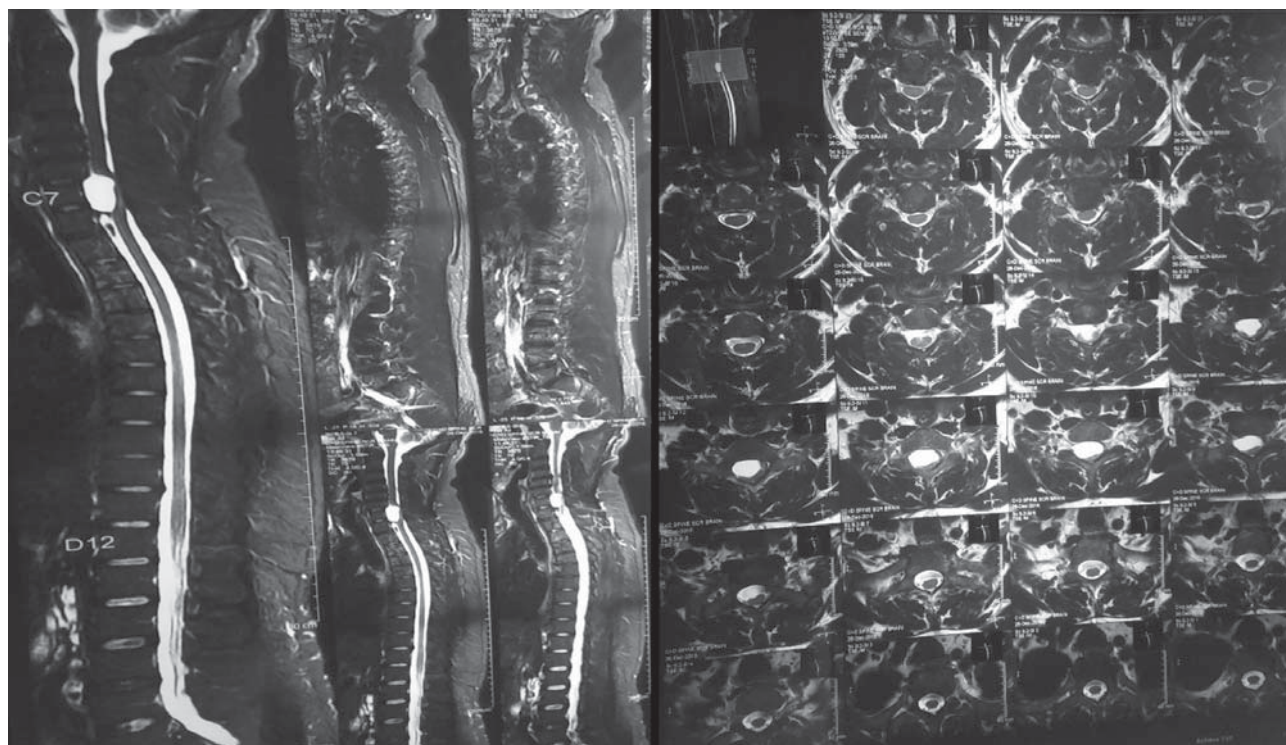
MRI showing T1 hypointense and T2 hyperintense ovoid non-enhancing intradural extramedullary cystic lesion located ventral to spinal cord at C7 level.
